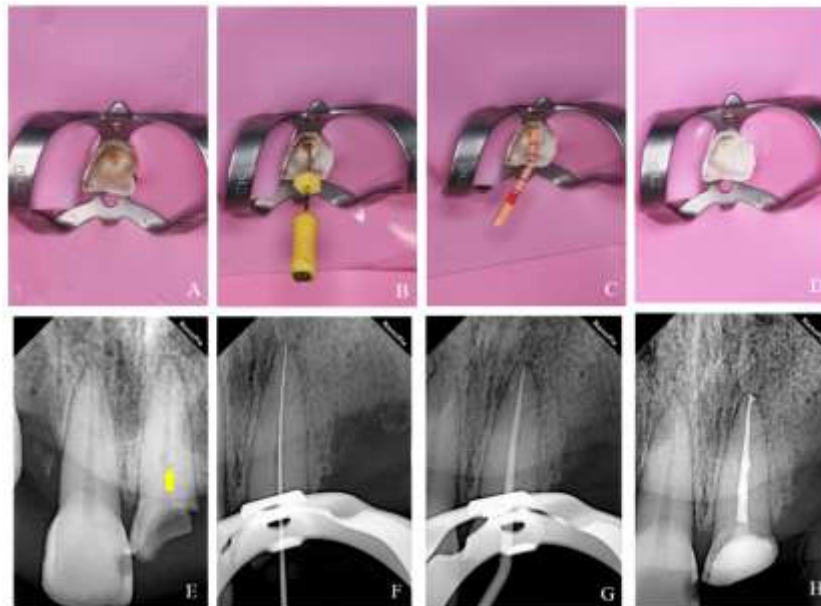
(A)Initial Examination tooth #21, (B)Initial Apical File, (C)Cone Fitting of Gutta-percha, (D)Obturation, (E)Initial Radiograph tooth #21, (F)Radiograph of Initial Apical File, (G)Radiograph of Cone fitting, (H)Radiograph of Obturation. (Source: personal documentation and patient consent for publication have been obtained)
